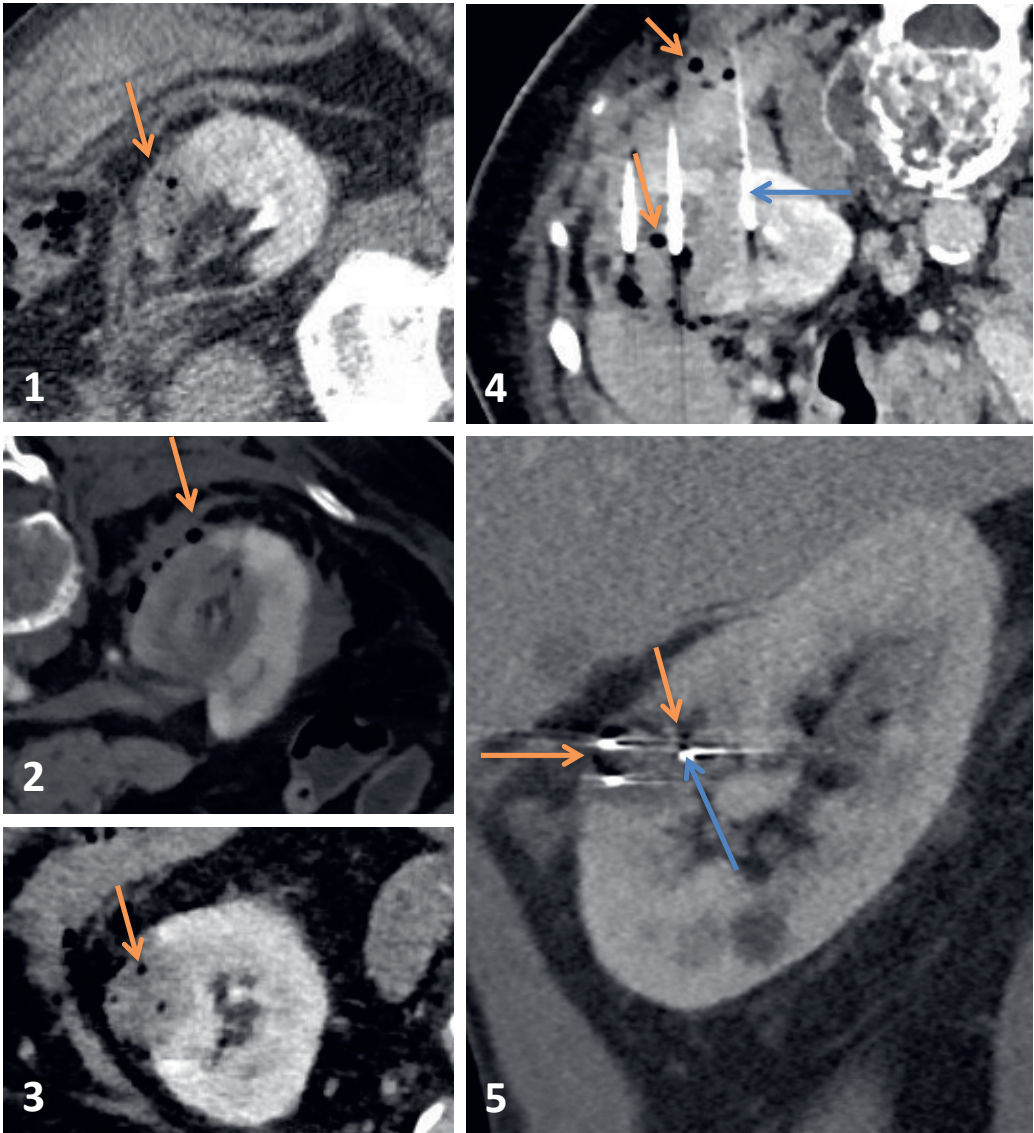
CT effects of IRE perioperatively (immediately after ablation): Notice the gas bubbles (orange arrows) in and around the hypodense ablation zone. Blue arrows point out the IRE electrodes punctured in the border of the the tumour.
